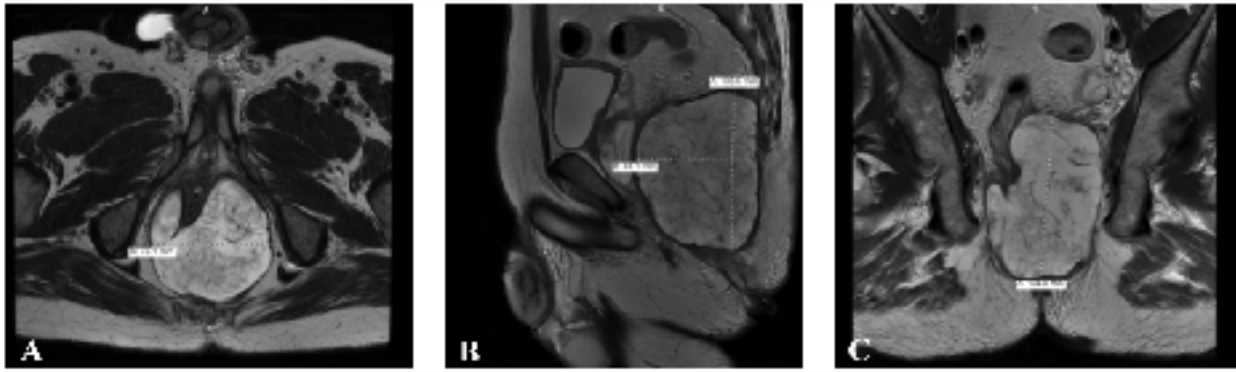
Showing different view of perianal mass in pelvic MRI.
